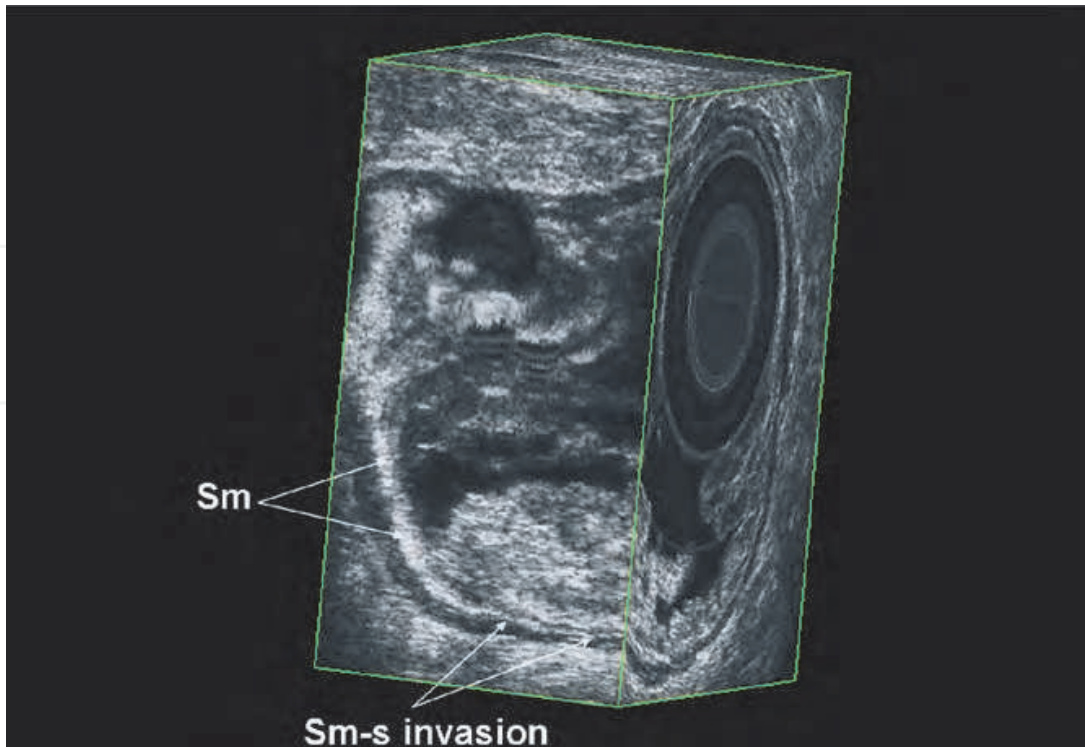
uT1-slight cancer are characterized at ultrasonography by a broadening of the first hypoechoic layer and a slightly irregularity of the hyperechoic submucosal interface
